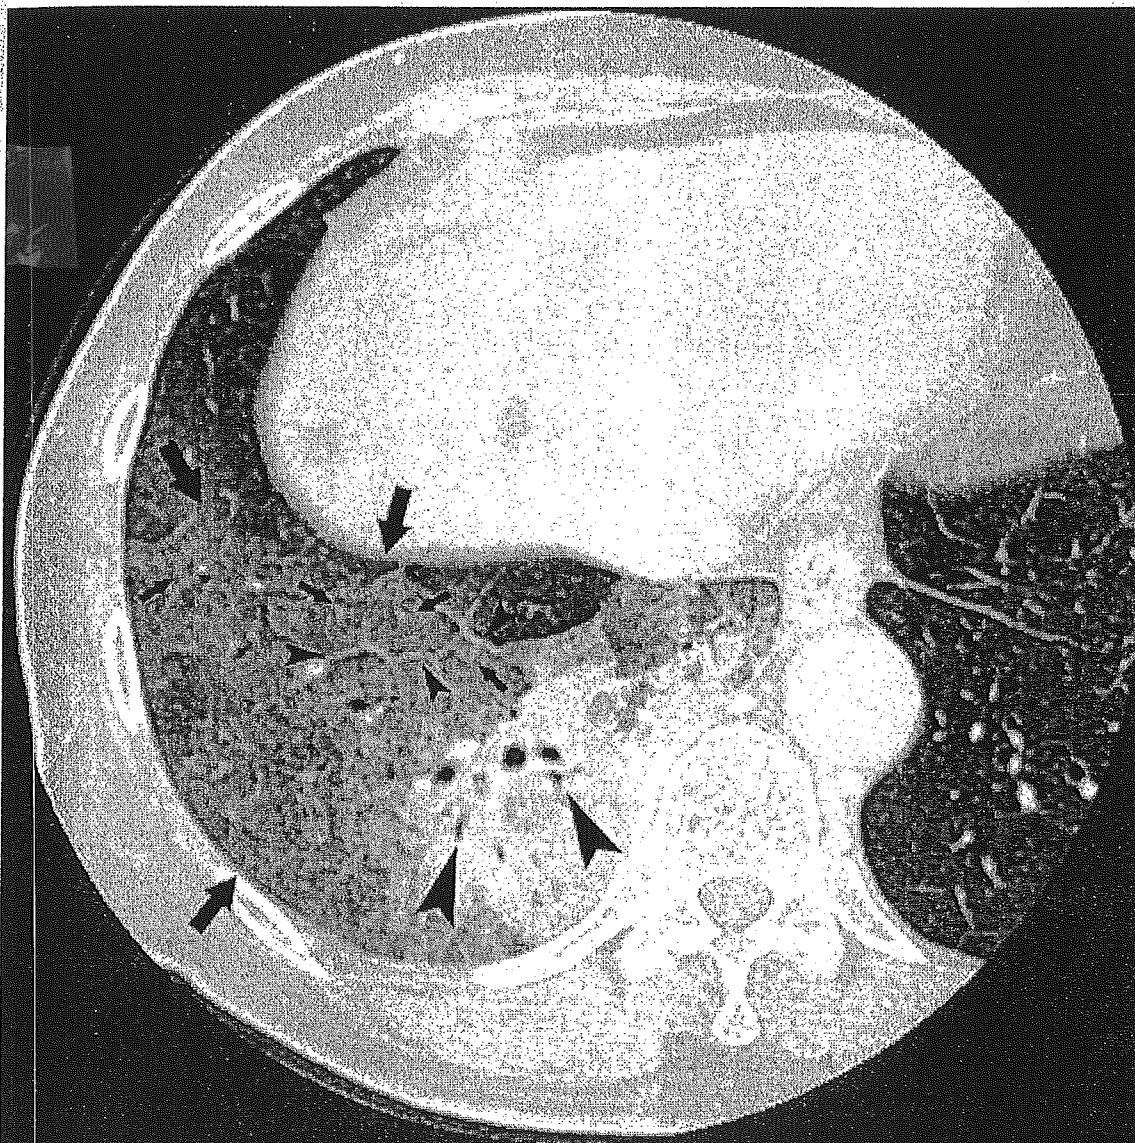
Mucin-producing adenocarcinoma of the lung in an 80-year-old woman. A computed tomography image shows a poorly demarcated mass with adjacent areas of ground-glass attenuation (large arrows). Also noted is the presence of an air bronchogram (large arrowheads), interlobular septal thickening (small arrowheads), and intralobular reticular opacities (small arrows).
